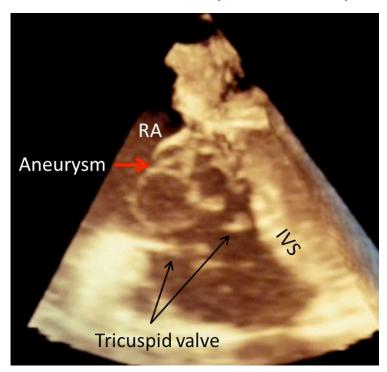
Transesophageal echocardiogram: 3D image showing aneurysmal aortic sinus tissue extending across most of the right ventricular inlet. RA-right atrium, IVS-interventricular septum.
